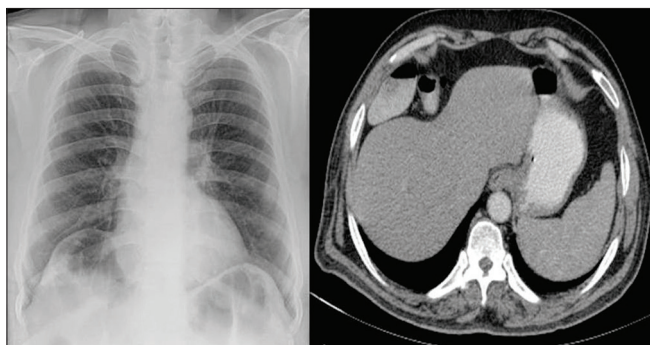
X-ray abdomen showing gas shadow with visible haustral folds in the right and left subphrenic space (left) and computed tomography scan showing interposition of colon between liver and both diaphragms (right)
